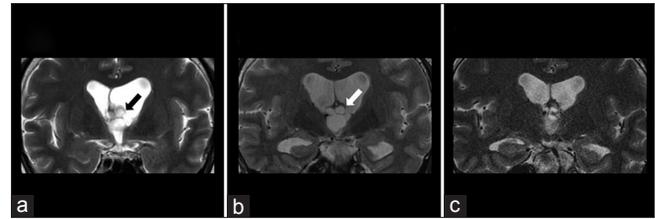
T2-weighted coronal magnetic resonance images. (a) The cystic lesion (black arrow) located in the third ventricle caused obstructive hydrocephalus with asymmetrical enlargement of the ventricles. (b) Preoperative image showing the asymmetrical enlargement of ventricles remained because of previous protrusion of the cyst into the left lateral ventricle regressed into the third ventricle (white arrow). (c) Postoperative image revealing the ventricular size decreased
